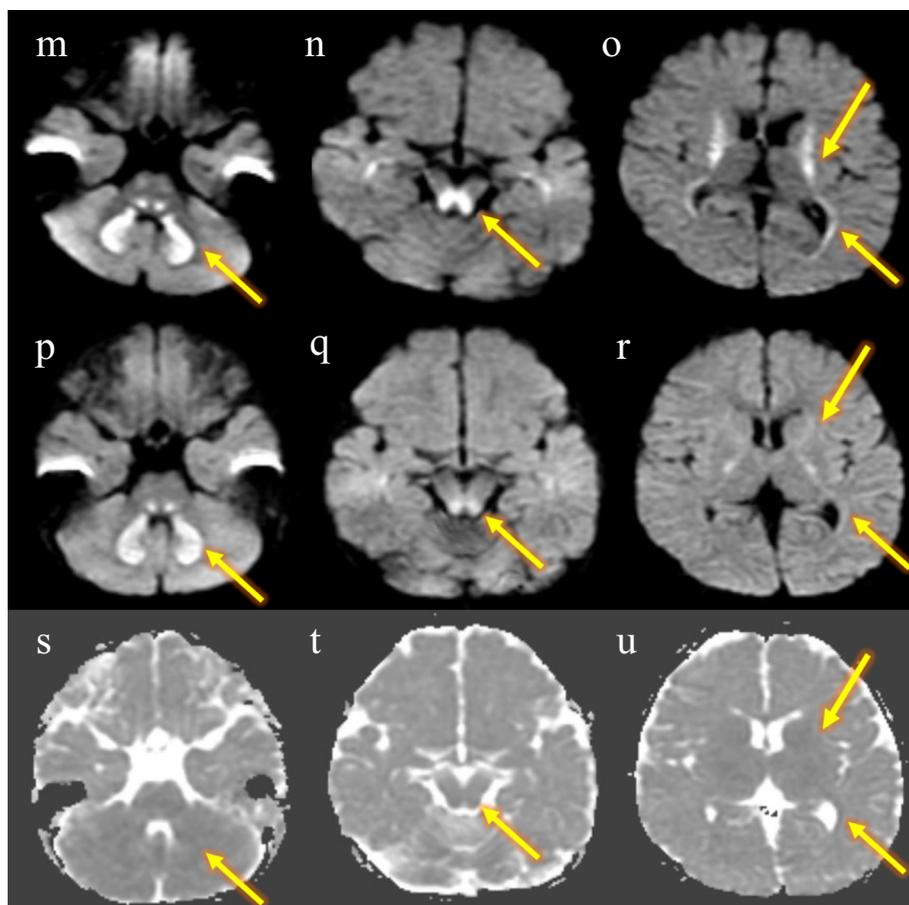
Serial DWI of the patient at the age of 7 and 13 months and ADC maps at the age of 13 months. Abnormal signals in the cerebellar white matter including dentate nucleus (m, p, s), dorsal midbrain (n, q, t), posterior limbs of the internal capsules, and cerebral white matter (o, r, u) are shown. Abnormal regions on DWI had spread at the age of 7 months (m, n, o); however, those in the dorsal midbrain (q) and posterior limbs of the internal capsules (r) were disappearing at the age of 13 months. There was no change in the cerebellar white matter including dentate nucleus on DWI at the age of 13 months (p). ADC values were slightly low in the same areas at the age of 13 months (s, t, u).
